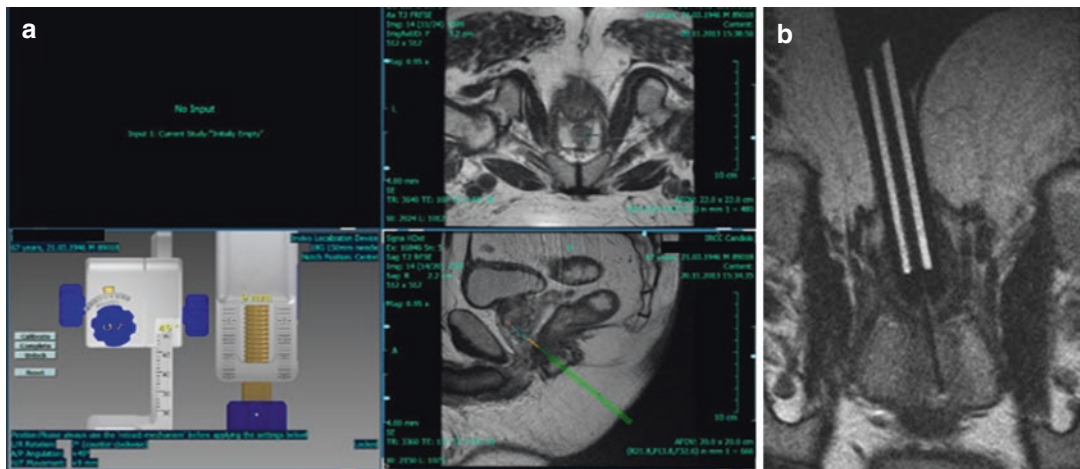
In-bore biopsy. (a) Needle-in control scans are performed in two different planes (axial and coronal); (b) targeted cores are taken from each lesion using an MRI-compatible, 18G, fully automatic biopsy gun
